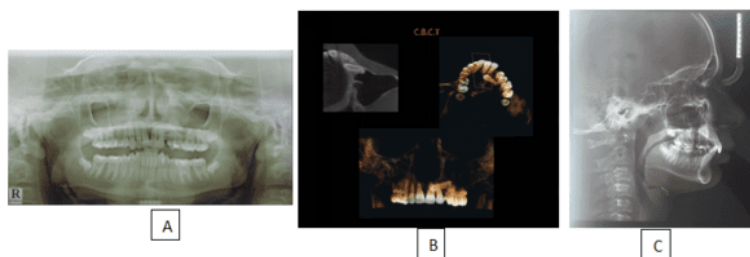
Pretreatment radiographs. A.OPG; B. Maxillary arch CBCT; C. Lateral cephalogram
